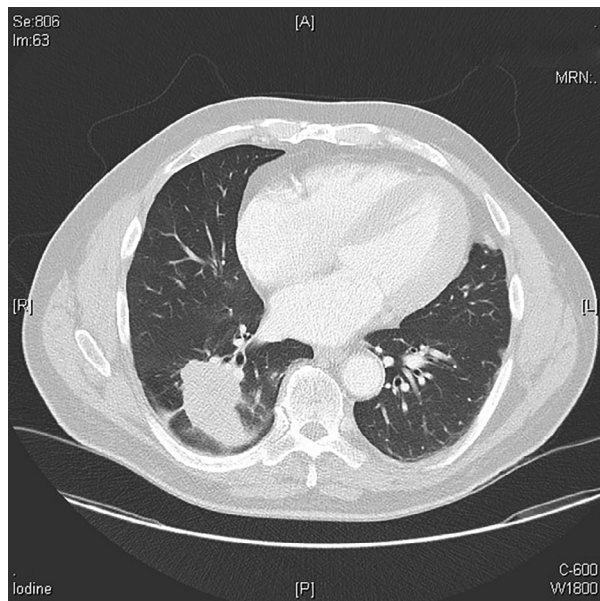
Computed tomography of the chest demonstrating primary lung lesion.
